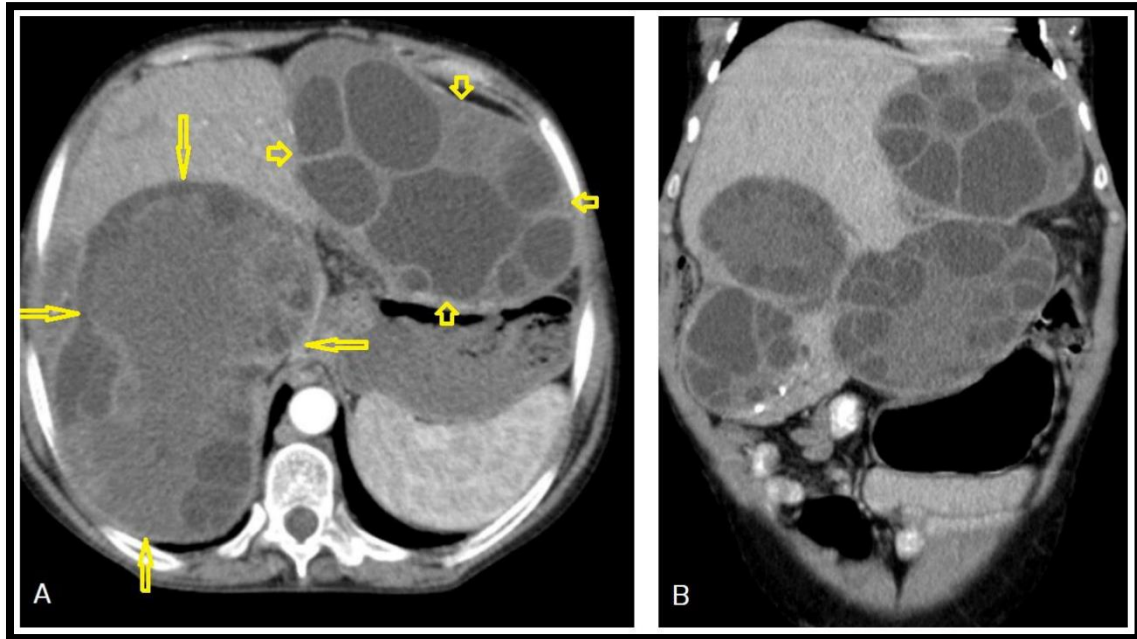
Show the axial (A) and coronal (B) CT images of a 55-year-old male showing multiple well-defined cystic lesions occupying the liver:
